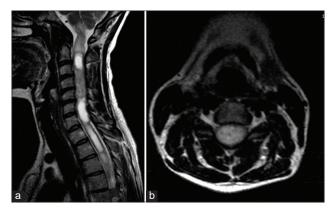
(a) Sagittal T2-weighted MRI showing an intradural, intramedullary lesion extending from C2 to C6 with an associated syrinx. (b) Axial T2-weighted MRI at the level of C4 showing the expansion of the spinal cord.
